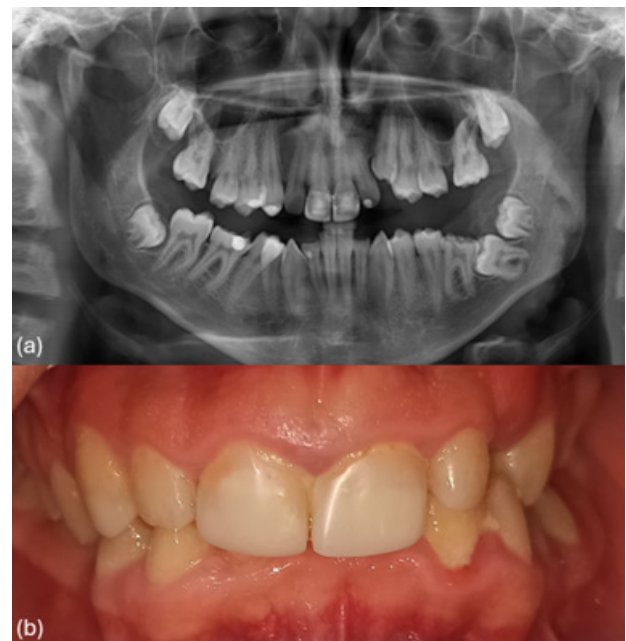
(a) Orthopantomogram taken in 2024, (b) Intraoral photograph taken in 2024
